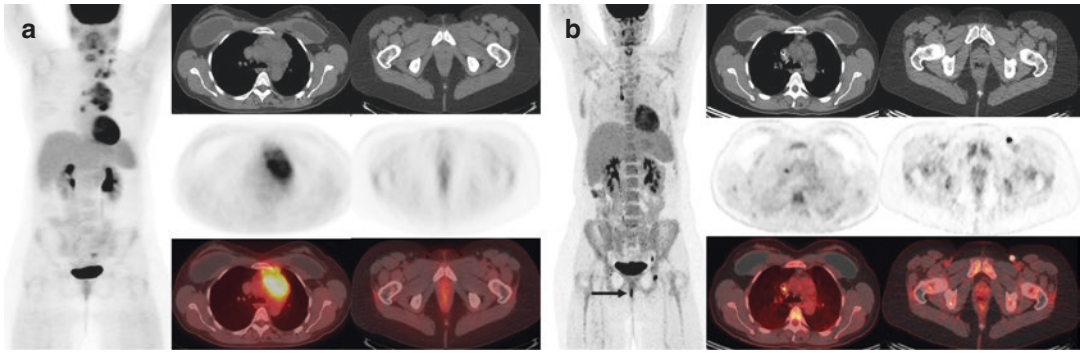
34-year-old woman with classical Hodgkin lymphoma. (a) Baseline FDG-PET/CT scan showed metabolically active left lower cervical, supraclavicular, and mediastinal lymph nodes, consistent with Stage II disease. (b) After 2 cycles of ABVD chemotherapy, the lymph nodes decreased in size and residual nodes had FDG
